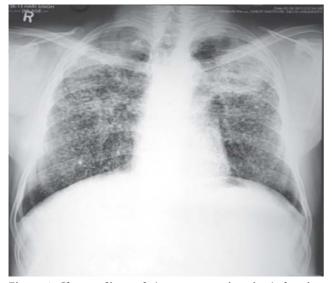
Chest radiograph (postero-anterior view) showing multiple nodular opacities along with progressive massive fibrosis with cavitation in both upper zones.
